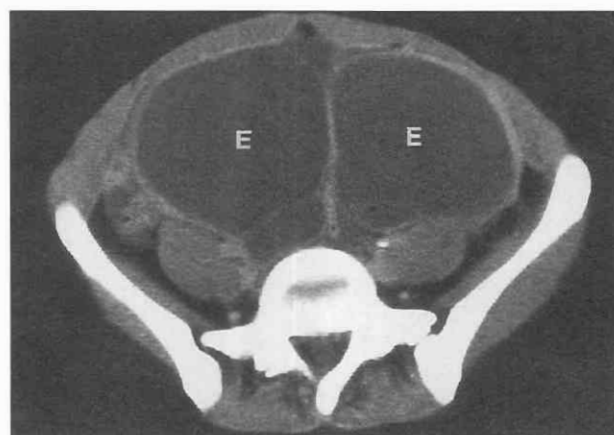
Endometriosis. CT scan through bilateral thick-walled giant ovarian endometriomas (E) in a 22-year-old woman with intermittent abdominal pain.
